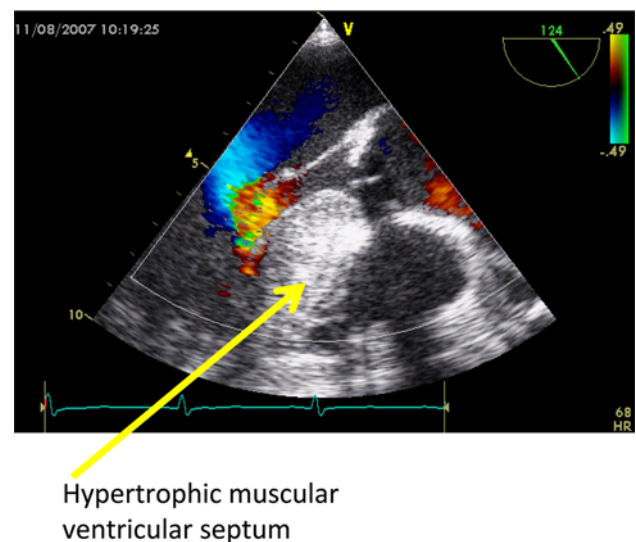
Transesophageal echocardiography during the operation. Hypertrophic muscular ventricular septum is shown
